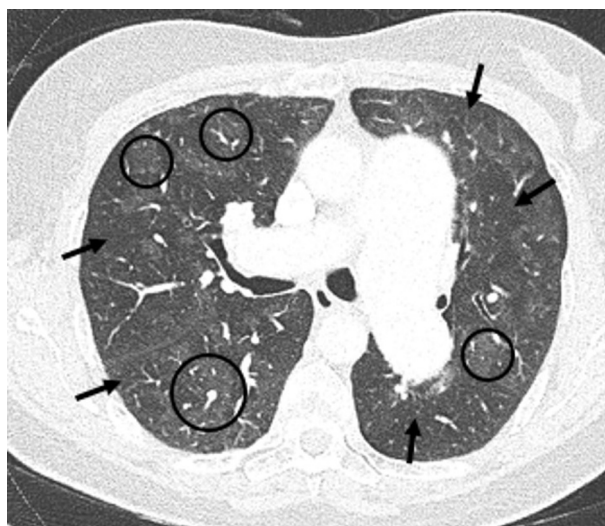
Axial CT scan of the chest showing alternating patchy areas of increased (circles) and decreased (arrows) attenuation. Mosaicism may be due to air trapping vs chronic thromboembolic disease or pulmonary arterial hypertension. Hypoattenuated areas due to both air trapping and vascular disease show decreased vasculature and may be difficult to differentiate. Occasionally, expiratory CT films may be helpful. If mosaicism is due to air trapping, the hypoattenuated areas will remain hypoattenuated on expiration. On the contrary, in vascular disease and pulmonary hypertension, the previously hypoattenuated areas will show an increase in attenuation and appear more gray.
